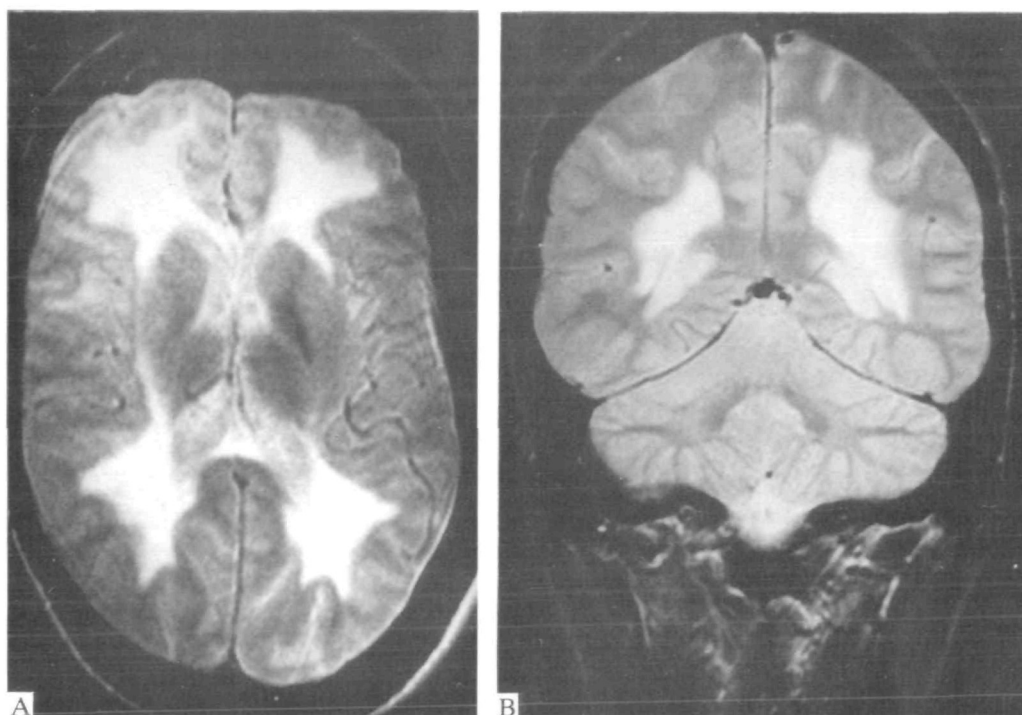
A, magnetic resonance imaging of brain from *Case II-2*, axial slice. TR = 2100 ms, TE = 60 ms. The cerebral white matter is conspicuous by abnormally high intensity signal. B, magnetic resonance imaging of brain, from *Case II-2*, coronal cut. TR = 2100 ms, TE = 60 ms. The abnormally high intensity signal of the cerebral white matter appears to spare the subcortical U fibres.
